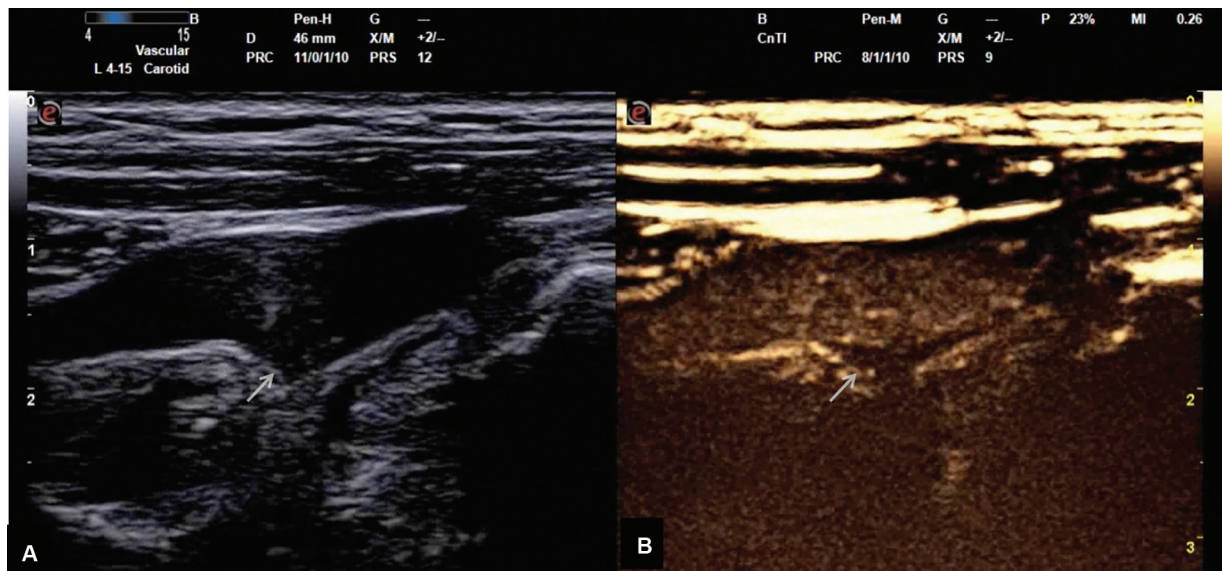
(A) Grayscale examination image of a patient in the case group depicting concentric plaque (indicated by arrow) located in the carotid bulb. (B) Contrast-enhanced ultrasound (CEUS) image shows enhancement in the periphery of the plaque as marked by the arrow.
